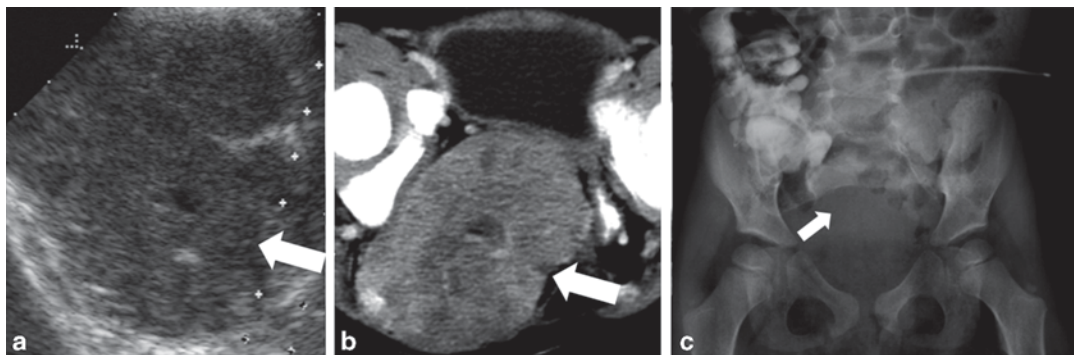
Currarino syndrome. Sagittal ultrasound image of the lumbosacral region (a), axial contrast enhanced CT image (b) and anteroposterior radiograph of the pelvis
